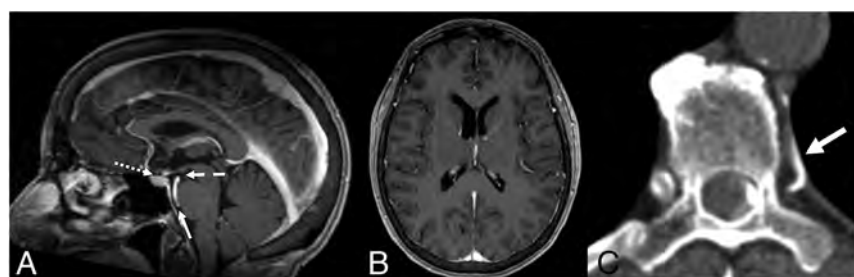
Brain MR imaging findings incorrectly reported as normal in a patient with spontaneous intracranial hypotension. A, Sagittal T1 postcontrast MR imaging demonstrates mild narrowing of the suprasellar (1 mm, *dotted arrow*), mamillopontine (4.8 mm, *dashed arrow*), and prepontine (3 mm, *solid arrow*) distances. B, No pachymeningeal thickening or subdural collection on axial T1 postcontrast MR imaging. C, Left-lateral decubitus dynamic CTM detected a CVF arising from the left T7–8 neural foramen (*arrow*).
